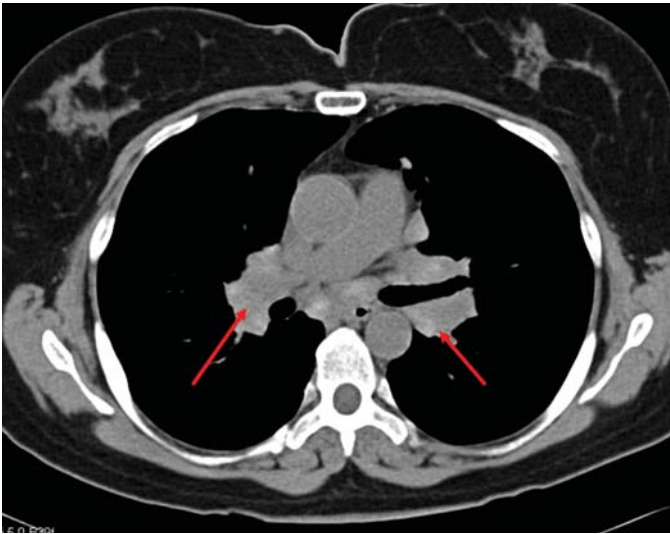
FIGURE e24-19 Sarcoid—CT scan of stage I demonstrating bulky hilar and mediastinal lymphadenopathy (*red arrows*) without parenchymal infiltrates.
